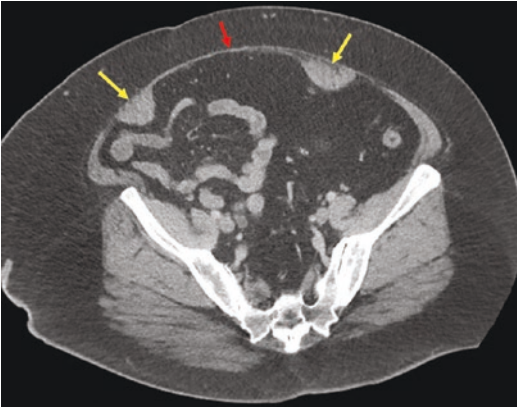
CT abdomen showing severe rectus diastasis with significant displacement of the rectus abdominis muscle bellies (yellow arrows). This patient also had a large ventral wall hernia inferior to the level shown
